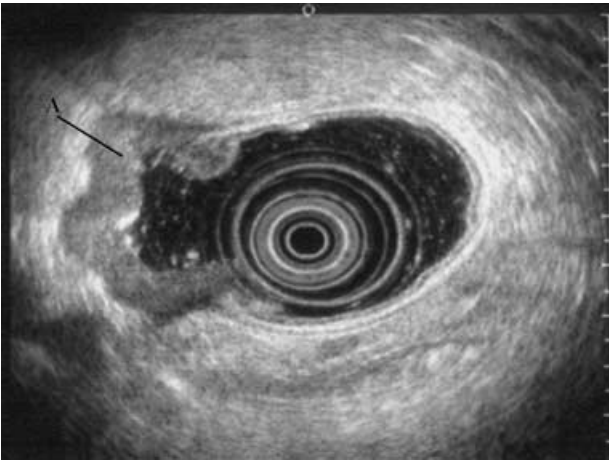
Endoscopic ultrasound appearance of T3 gastric cancer, in which the tumor had gone beyond the muscularis propria (A).
